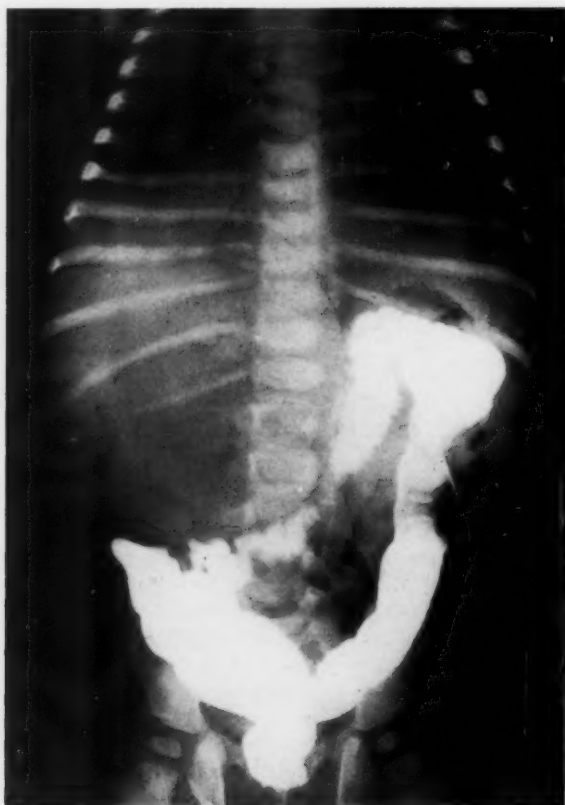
Preoperative roentgenogram after barium enema, showing the marked displacement of the colon medially and inferiorly by the large mass occupying the right upper abdomen. As pointed out by Hofmann, this is a most important sign in the diagnosis of liver cysts.
